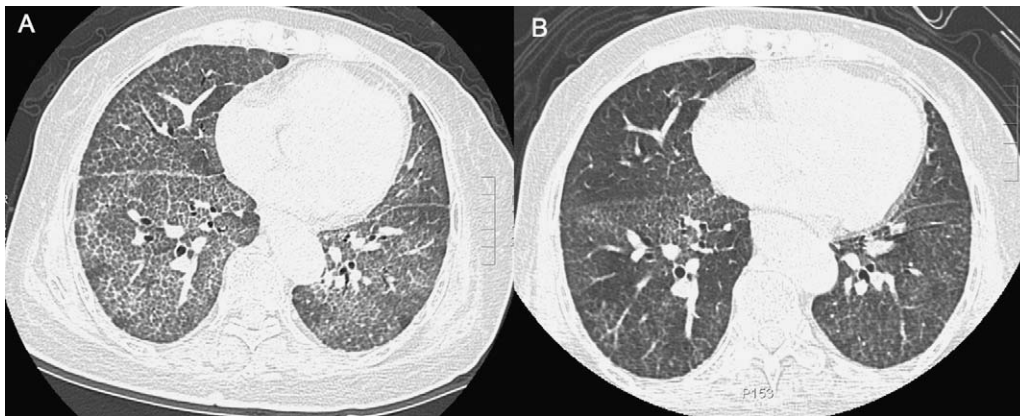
The initial high-resolution computed tomography of the chest showed bilateral interlobular septal thickening on a background of ground-glass opacity in a crazy-paving pattern (A), which improved significantly after a 5-month antifungal therapy (B).
